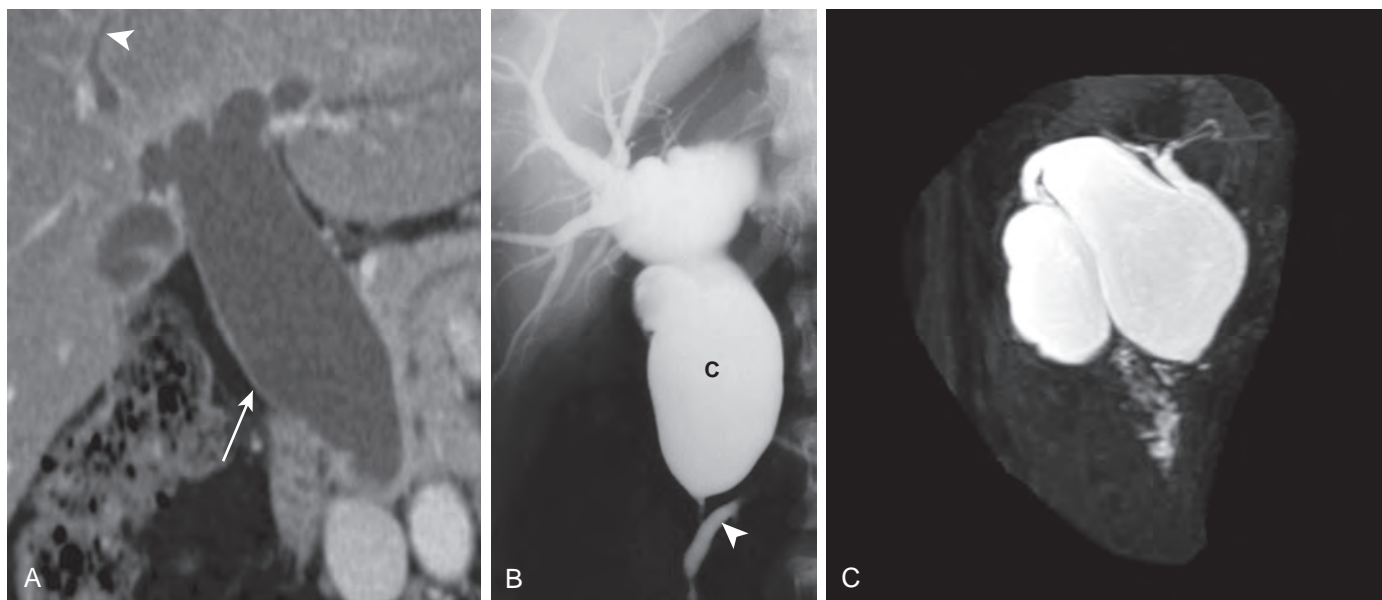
Type I choledochal cysts. A. Coronal oblique multiplanar reformatted CT image shows fusiform dilation of the common bile duct (arrow). Note also the dilation of the intrahepatic biliary tract (arrowhead). B. Percutaneous transhepatic cholangiogram in the same patient shows a large choledochal cyst (c) at the level of the extrahepatic bile duct. Note the aberrant entry of the common bile duct at the side of the pancreatic duct (arrowhead). C. MRCP in a different patient shows a dilated main common bile duct.
